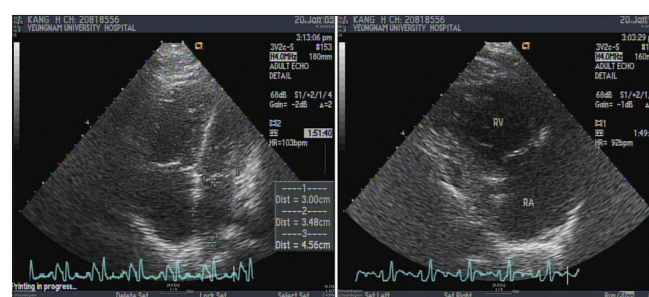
Postoperative transthoracic echocardiography in case 1. Echocardiography reveals distension and enlargement of the right atrium and ventricle with D-shaped left ventricle
